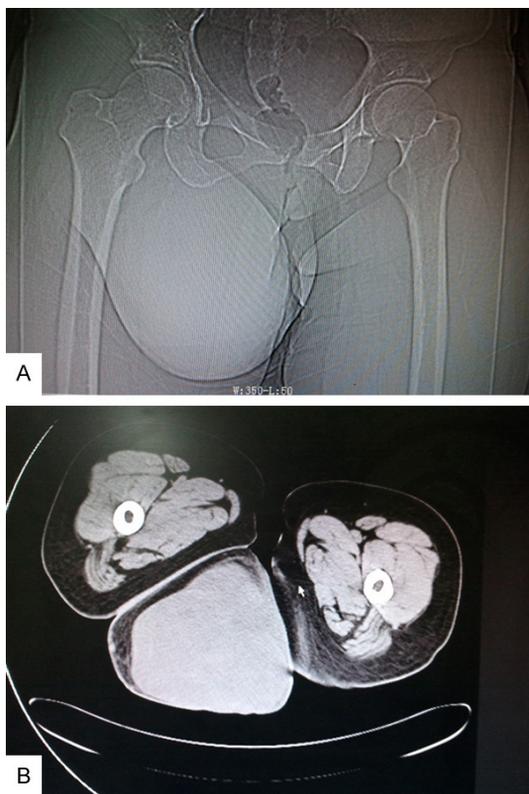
X-ray and CT findings. A. X-ray showing a large mass in the right hip. B. CT showing a large conglomeration shadow in the right hip, protruding into the pelvic cavity and causing local rectal and uterine compression. CT = computed tomography.
